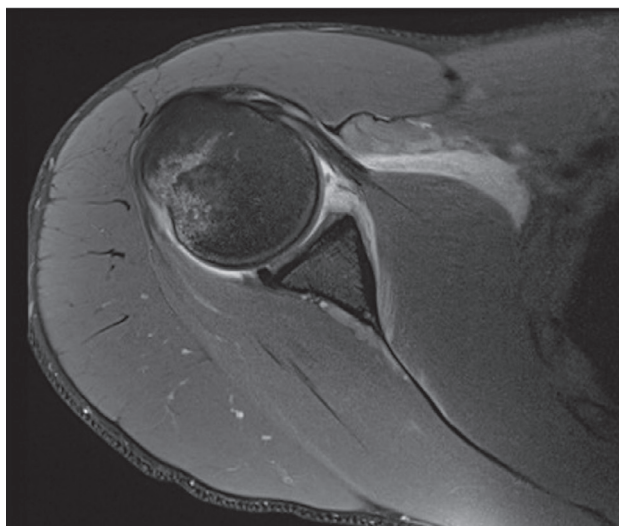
Axial T2-weighted image of the right shoulder. There is cortical irregularity at the postero-lateral aspect of the humeral head, associated with high signal within the bone marrow, in keeping with marrow oedema. These findings demonstrate a Hill–Sachs lesion.
